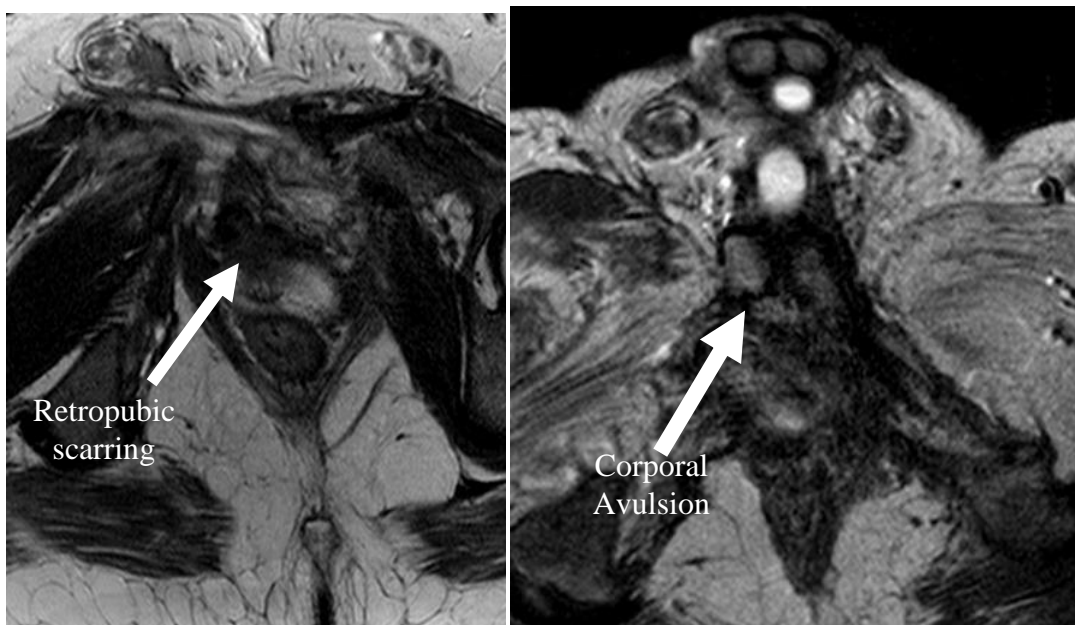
and 19 Retropubic scarring and corporal avulsion on MRI
